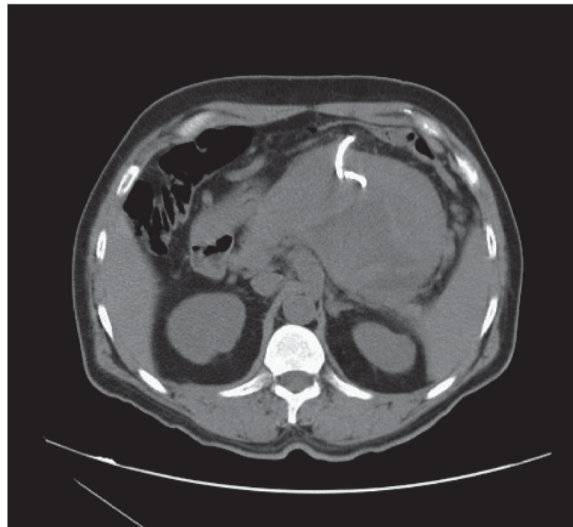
CT scan done after traumatic injury, drainage tube can be seen.
